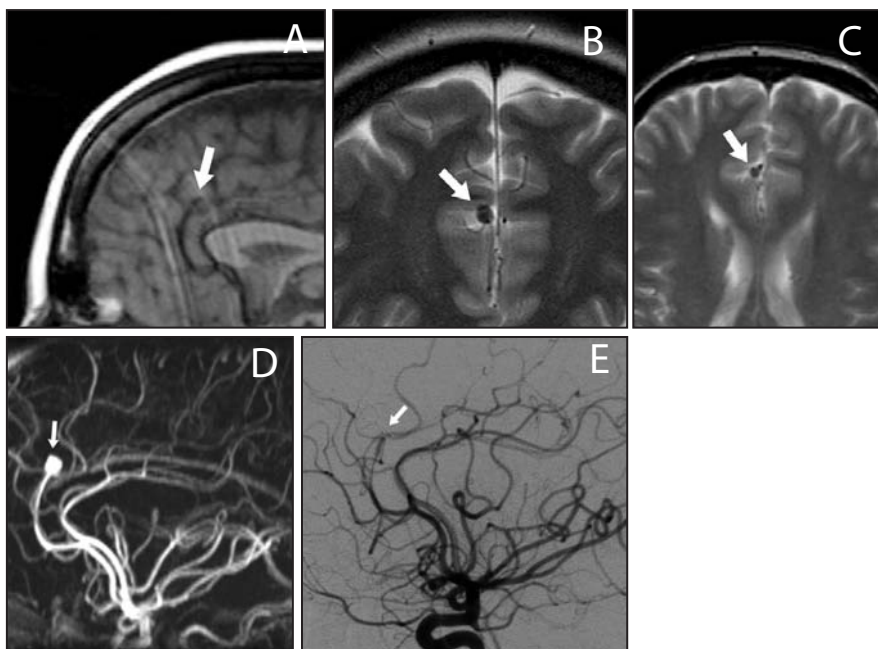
Unruptured distal CMA aneurysm (arrow) as seen on preoperative (A) sagittal, (B) coronal, and (C) axial MRI images with the aneurysm in the cingulate sulcus. (D) Preoperative MRA and (E) postoperative DSA show aneurysm location at the bifurcation of the distal CMA.
